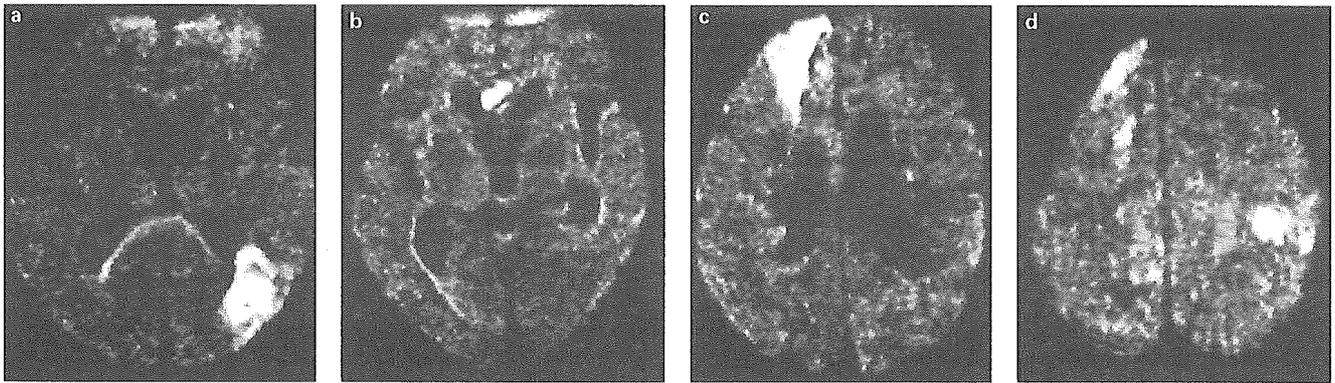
a Diffusion-weighted axial MRI performed 5 days after the onset of right hemiparesis, which occurred 13 months before death, shows a hyperintensity area in the left parietal lobe. b–d Diffusion-weighted MRIs performed 6 days after the onset of somnolence and left hemiparesis, which occurred 20 days before death, reveal hyperintensity areas in the right frontal lobe, corpus callosum and left parietal lobe.
